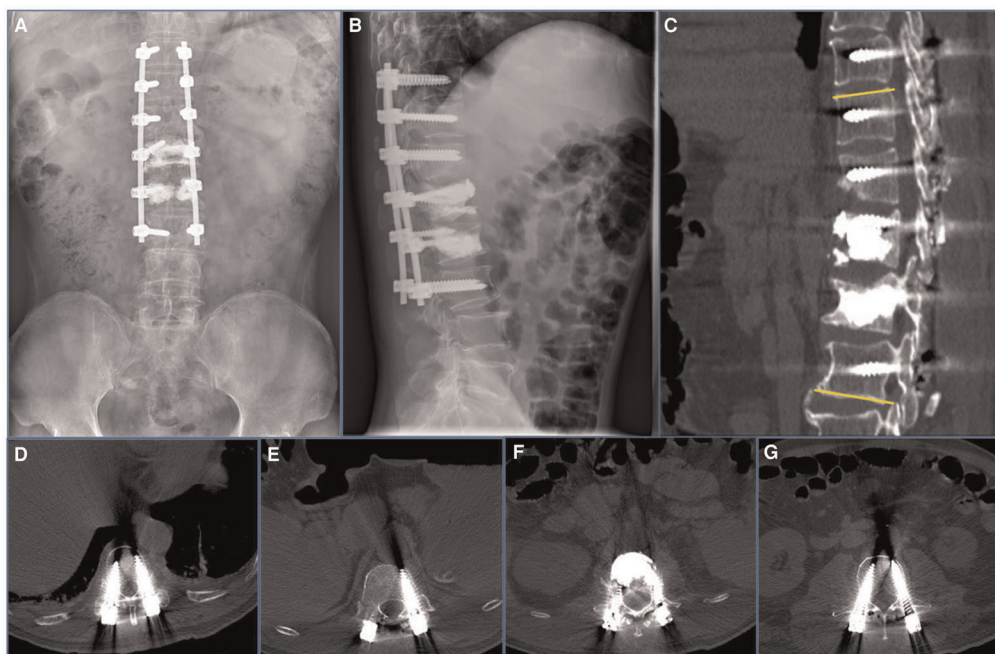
Imaging features after initial surgery at our hospital. (A,B) Postoperative 1-week radiograph indicated alleviation of the kyphosis. (C–G) Postoperative 1-week CT scan indicated good internal screw fixation (Cobb's angle: 10°).
